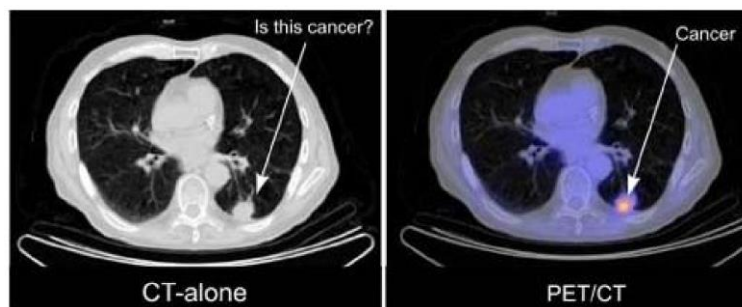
CT (left) and PET-CT (right) scan images of the lungs^[17].
